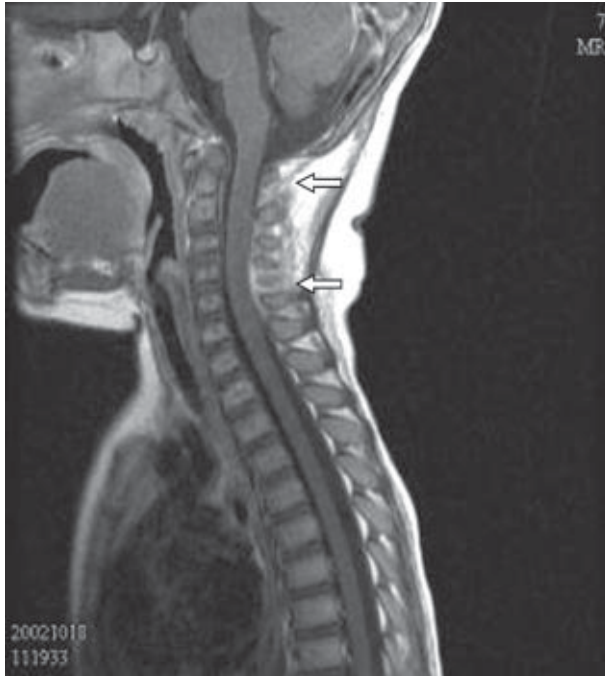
Sagittal T1-weighted magnetic resonance imaging after intravenous gadolinium-diethylenetriamine pentaacetic acid administration shows abnormal enhancement in the interspinous space at the C2 to C5 level (arrows).
